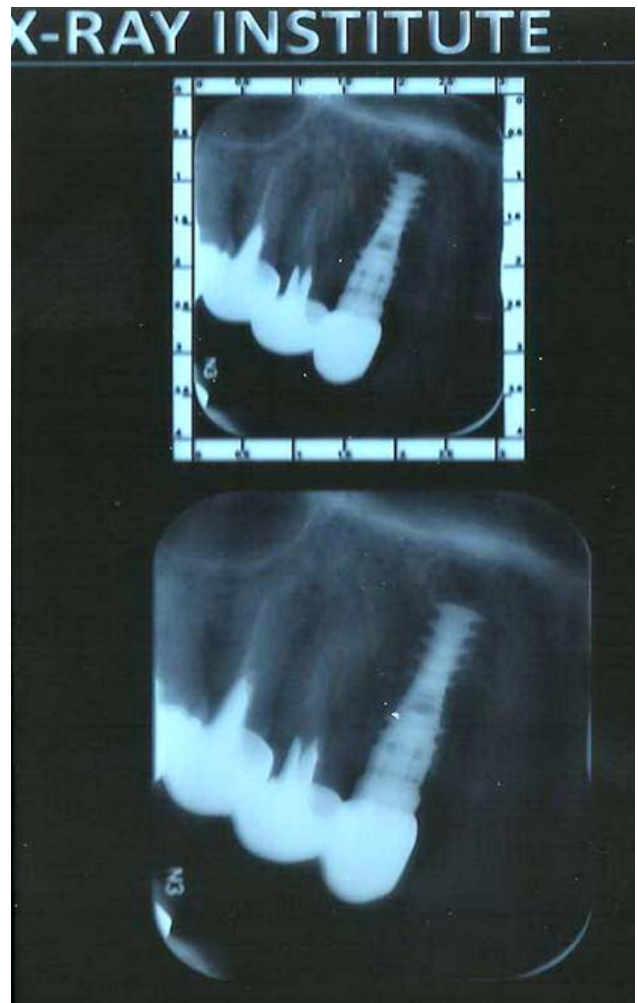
Radiographic view of the implant and cemented crown 3 years after treatment
